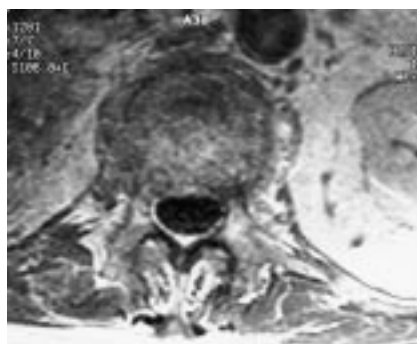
Images of a 72-year-old woman with sudden onset of severe thoracolumbar pain without trauma. Top, Sagittal T1-weighted image shows marked homogeneously decreased signal intensity with posterior bulging of the vertebral cortex into the canal. Bottom, Axial T1-weighted image shows that abnormal signal changes extend into both pedicles. Both T2-weighted images were interpreted as suggestive of tumor infiltration of the vertebral body, but biopsy revealed only osteoporosis.
